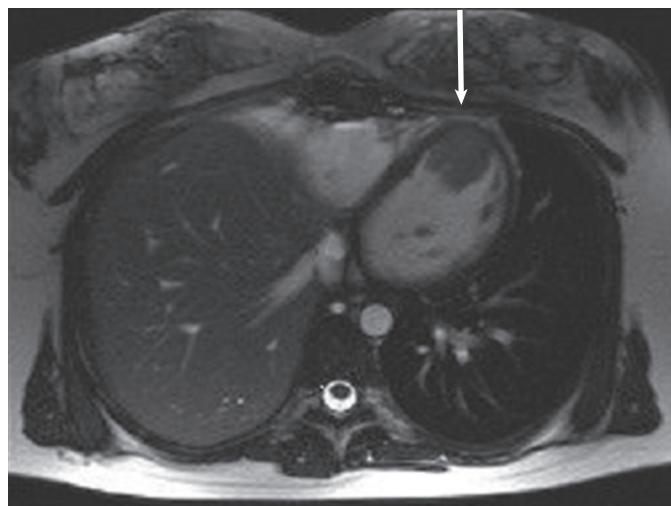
T1-weighted cardiac MRI of a left ventricular apical tumor of metastatic alveolar cell sarcoma. Note the indistinct nature of the tumor infiltrating the myocardium (arrow). This is in contrast to the distinct line that classically separates thrombus from myocardium.
